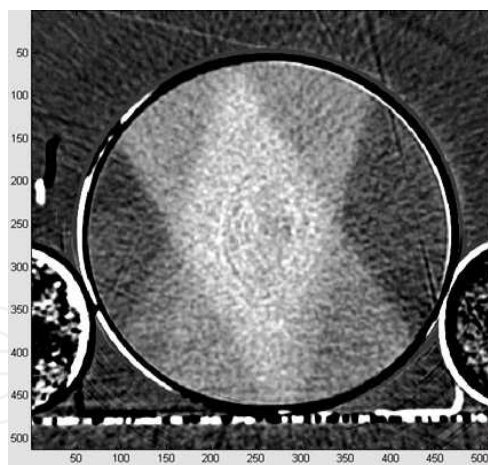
X-ray CT image of gel in PET container irradiated with four intersecting $4 \times 4\text{cm}^2$ 6MV field doses of 2, 5, 7, and 11Gy at the depth of maximum dose. This image was obtained after background subtraction and image averaging.
